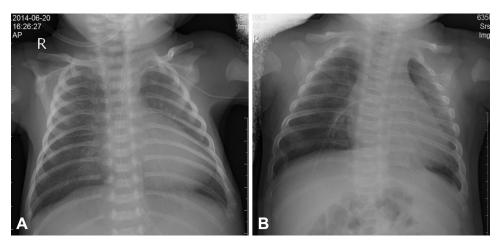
Chest radiograph (CXR) of the patient. A. Posteroanterior CXR showing that the end of the PICC is at a normal site in the superior vena cava. B. The rechecked posteroanterior CXR revealing that the fractured end of the PICC has shifted into the right lower pulmonary artery.
